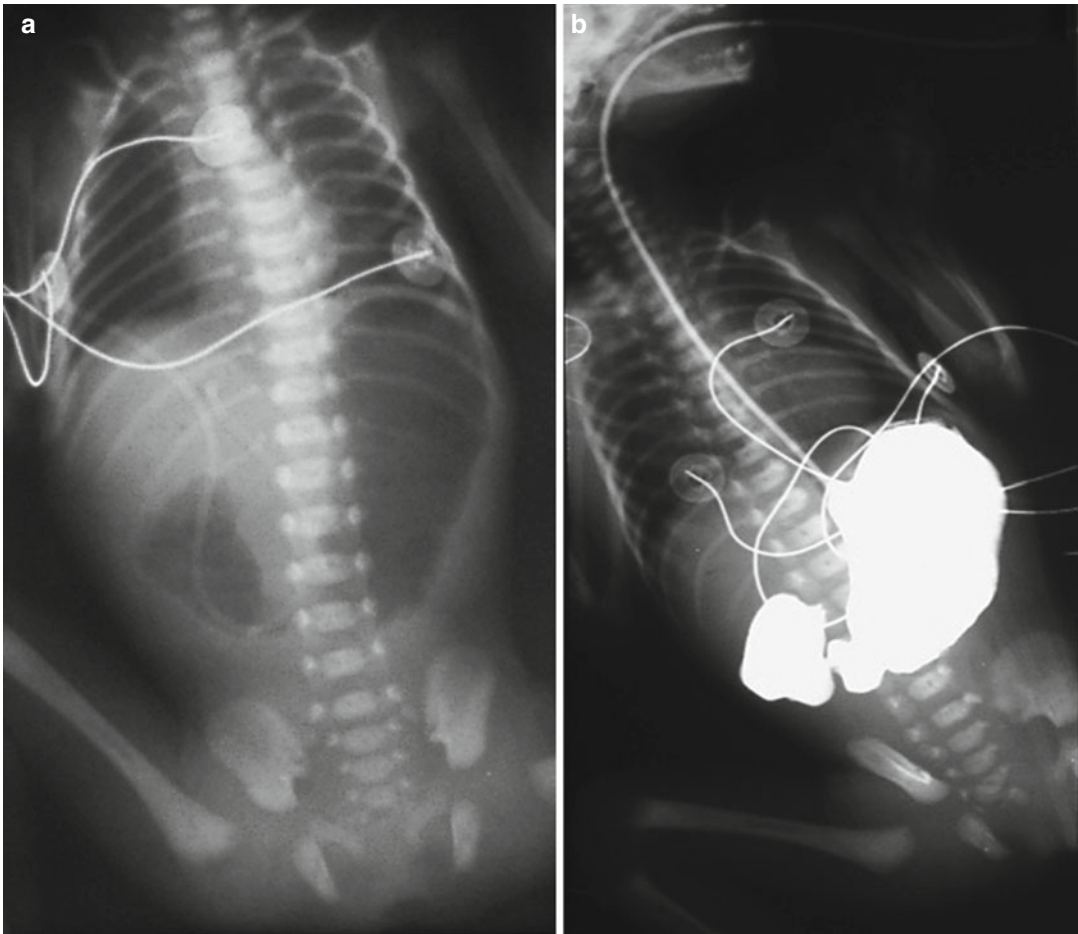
(a) Plain film shows gas distention of the stomach and proximal duodenum; no gas is seen in the rest of the abdomen. (b) Barium study confirms the duodenal atresia with the double bubble sign
